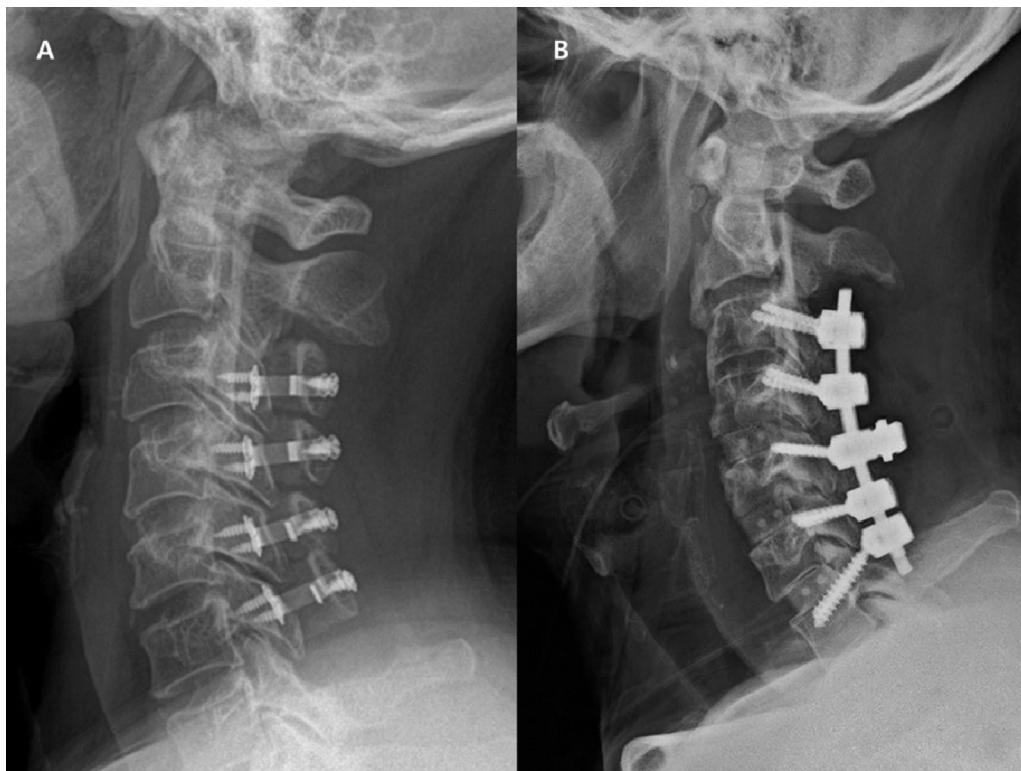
Postoperative lateral cervical spine radiographs of patients with ossification of the posterior longitudinal ligament (OPLL) following posterior cervical surgery. A Cervical laminoplasty (LP), B Staged anterior and posterior fusion (APF). LP, cervical laminoplasty; APF, Staged anterior and posterior fusion; OPLL, ossification of the posterior longitudinal ligament
